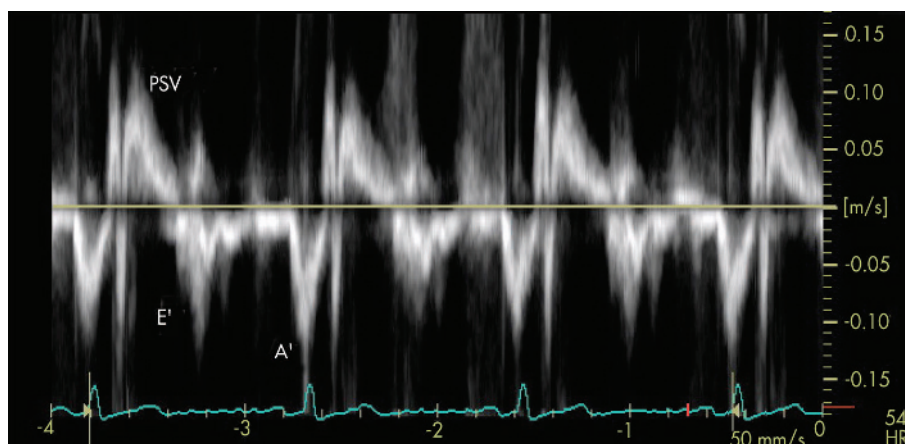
Tracing derived from pulsed wave tissue Doppler with the sample placed at the level of the tricuspid annulus of the RV free wall, demonstrating peak systolic velocity (PSV), and diastolic parameters (E' and A').
